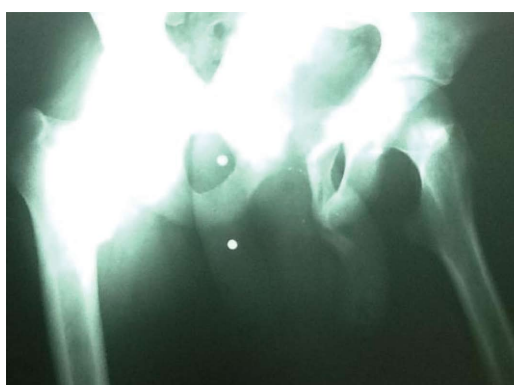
X-ray views demonstrating bone allograft construct within the substance of the neophallus.
